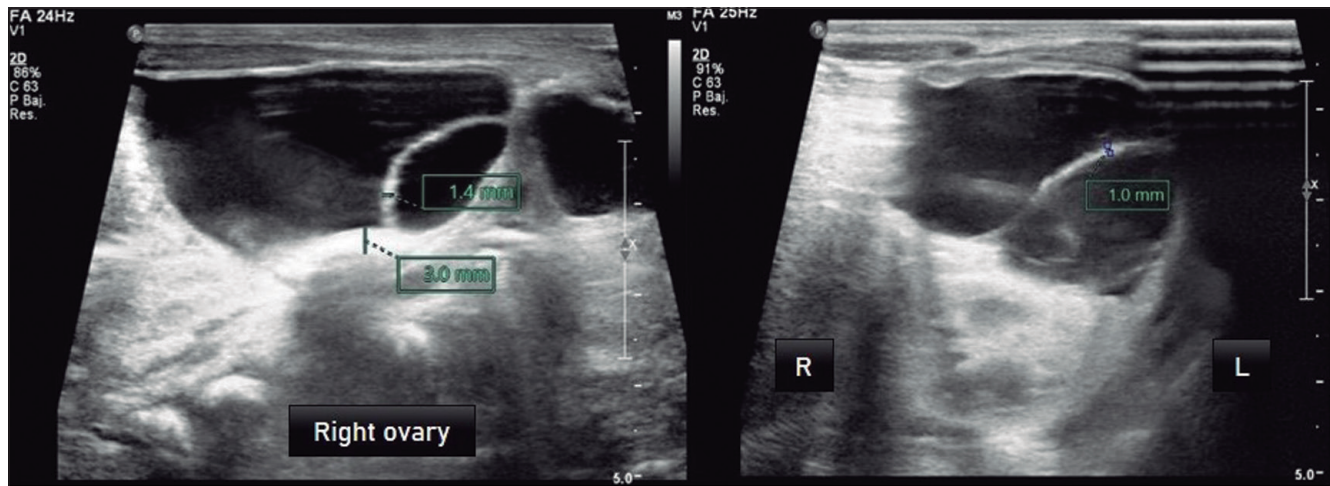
Postnatal ultrasound in the first 24 hours of extrauterine life. Ovarian cysts of 3.4x2.4x3.3 cm, 14.7 mL in volume with a 1 mm septum (left), and 3.5x4.4x2.7 cm, 23 mL with 1.4 mm septum (right).
